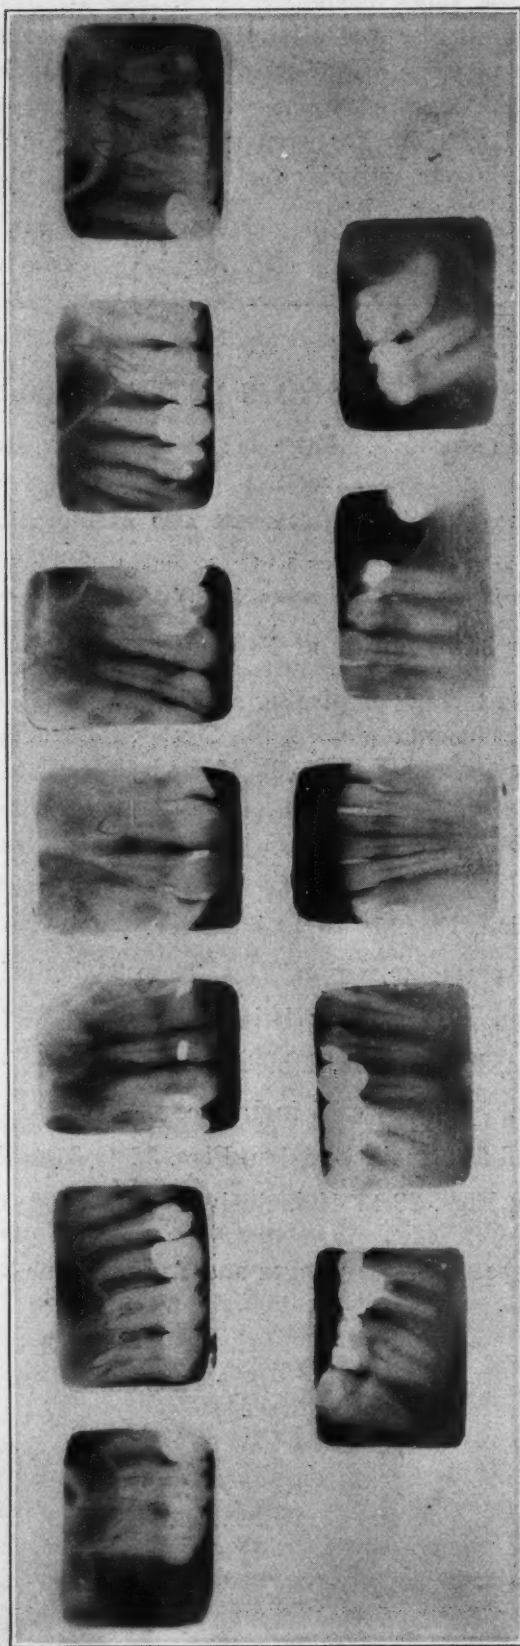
A 12-negative radiographic survey of the mouth. Holder No. 1 was used for all the maxillary teeth, No. 3 for the incisors and No. 2 for the others.
